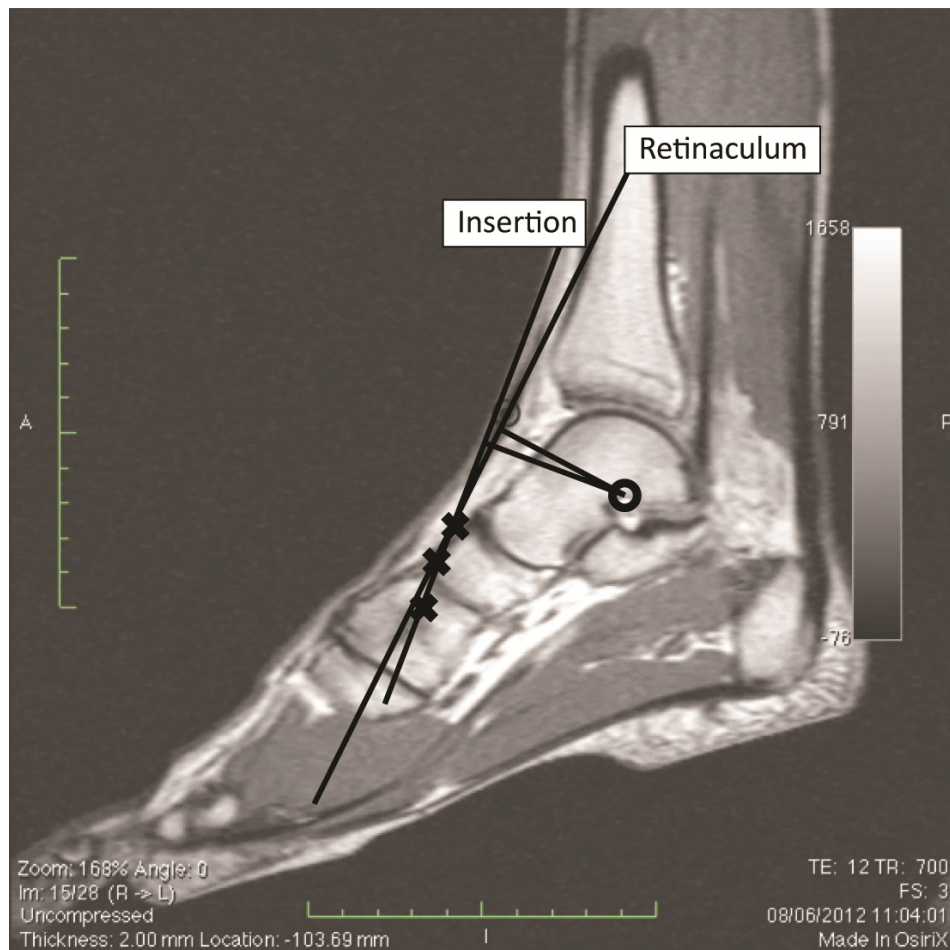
Two approaches to modelling the line of action of the tibialis anterior tendon were used. The first used a straight line connecting the proximal and distal points on the tendon slice at the retinaculum (labelled *Retinaculum*). The second (labelled *Insertion*) modelled the line of action as a linear fit being fitted to the 2D (sagittal plane) coordinates of the centroid of the tendon slice within the three MRI slices proximal to the slice in which the insertion first became observed.
